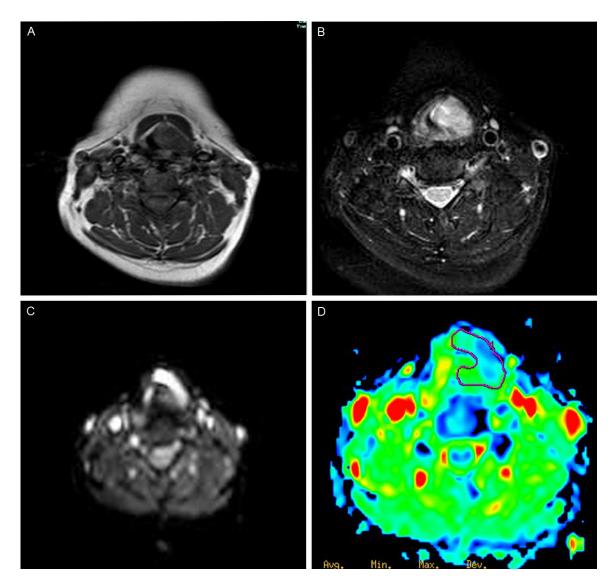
MRI showed an irregular mass overlying the left false cord, vocal cord, and piriform sinus, and no enlarged node was present. T1-weighted imaging showed isointensity (A), and T2-weighted imaging showed hyperintensity (B). Diffusion-weighted MRI (DWI) showed that the lesion had high signal intensity (C), and the apparent diffusion coefficient (ADC) was $1.18 \times 10^3 \, \text{mm}^2/\text{s}$ (D).
